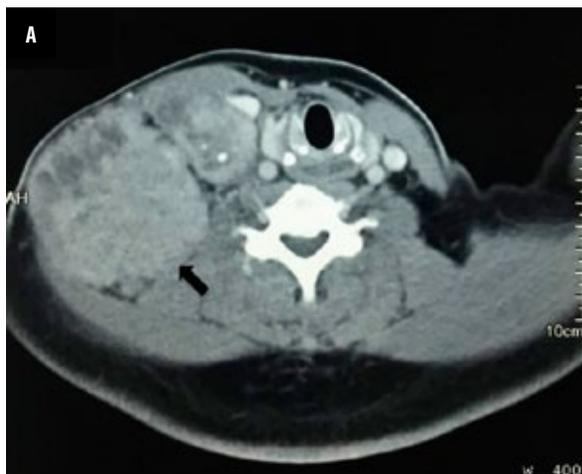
A. Axial view of CT scan showing a heterogeneous mass at posterior triangle (black arrow); B. Coronal view of CT scan showing a similar mass (black arrow)
